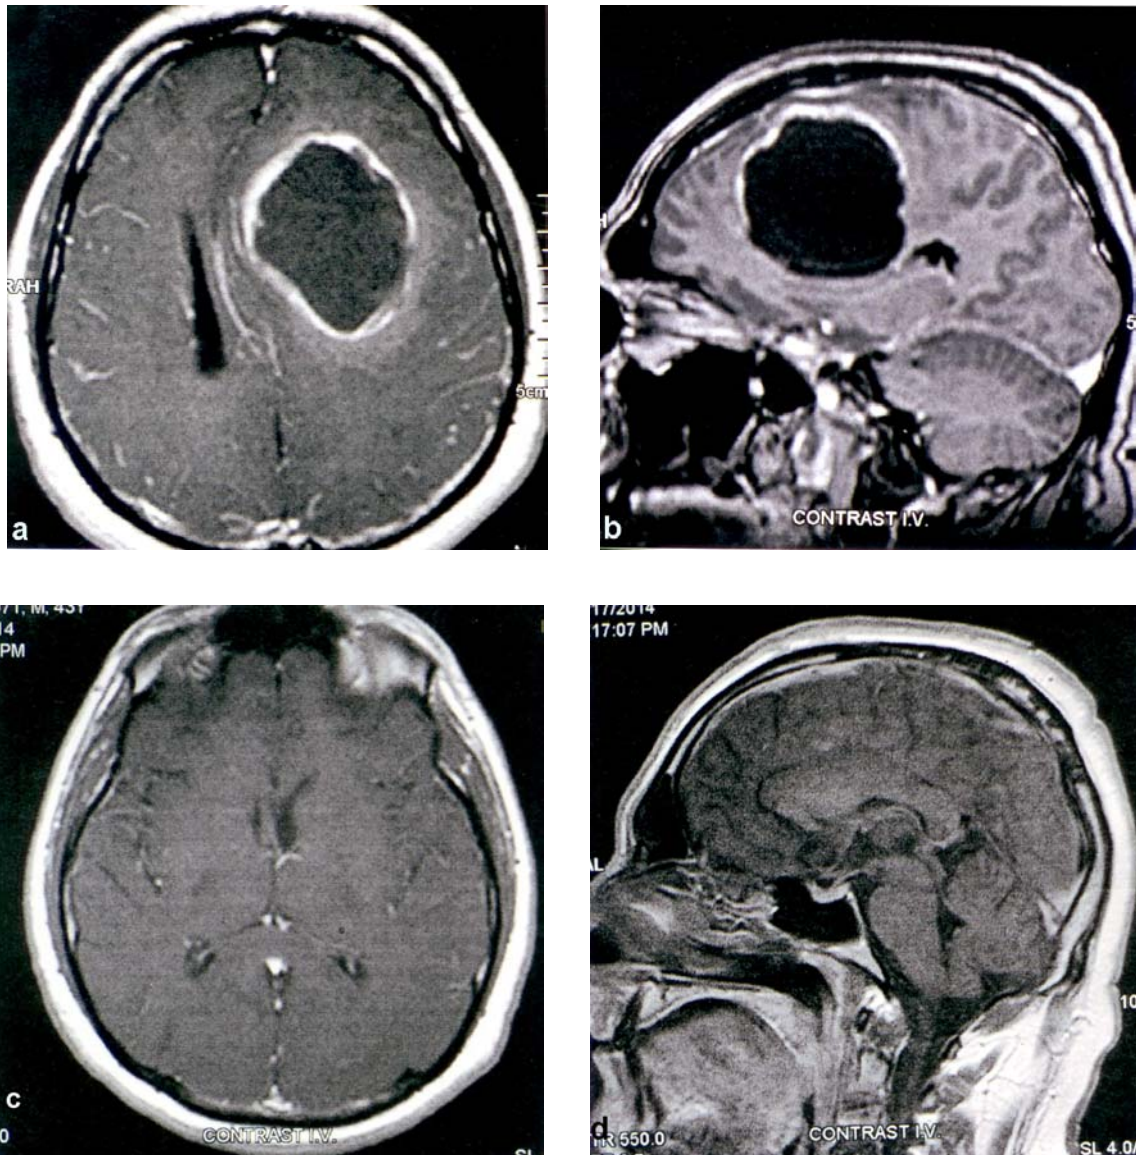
A 43-year-old woman who had presented with a 2-month history of moderate weakness on the right side, headache, the degradation of the sense of pudency and other disorders specific to lesions of the dorsolateral prefrontal cortex which had been described in the text. The preoperative computed tomography (CT) scan shows the presence of a well-circumscribed left side frontal cystic astrocytoma (a and b). The postoperative CT scan demonstrates the complete removal of the tumour (c and d) (surgeon Leon Danaila). After four months the frontal syndrome had disappeared.
